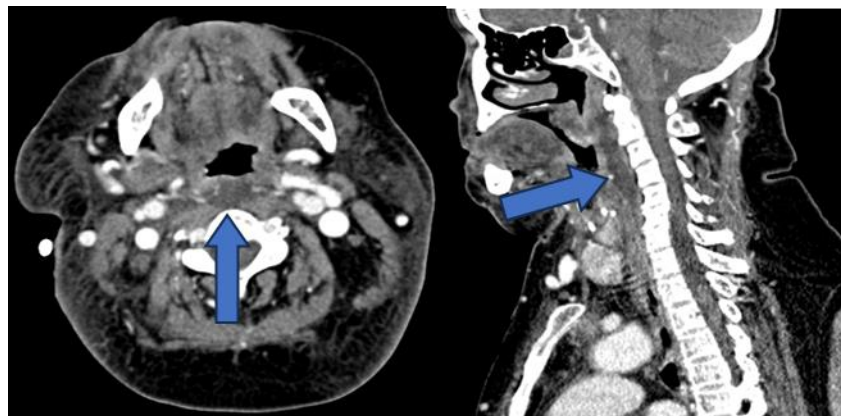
Contrast enhanced CT neck in axial and sagittal view showed retropharyngeal space collection with surrounding fat streakiness extending from C2 to C6 vertebrae level (Arrow).
